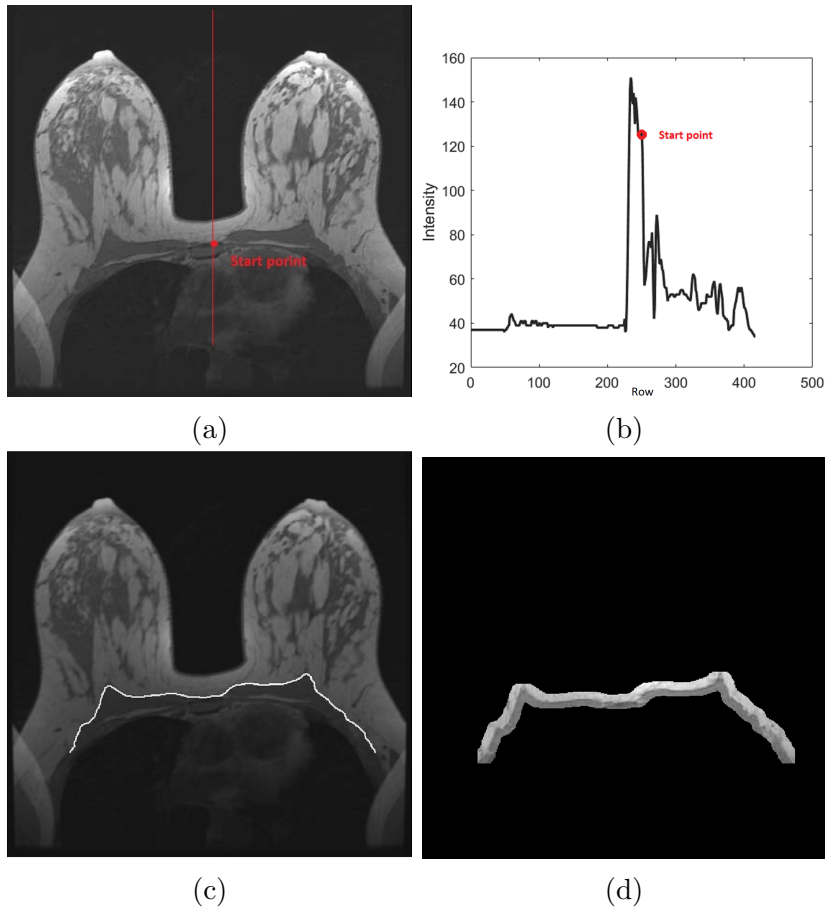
(a) Axial slice of a T1-weighted MRI volume; (b) Intensity variation of (a) along the middle column (red-line); (c) Detected pectoralis-breast boundary; and (d) Masked neighbouring slice.
